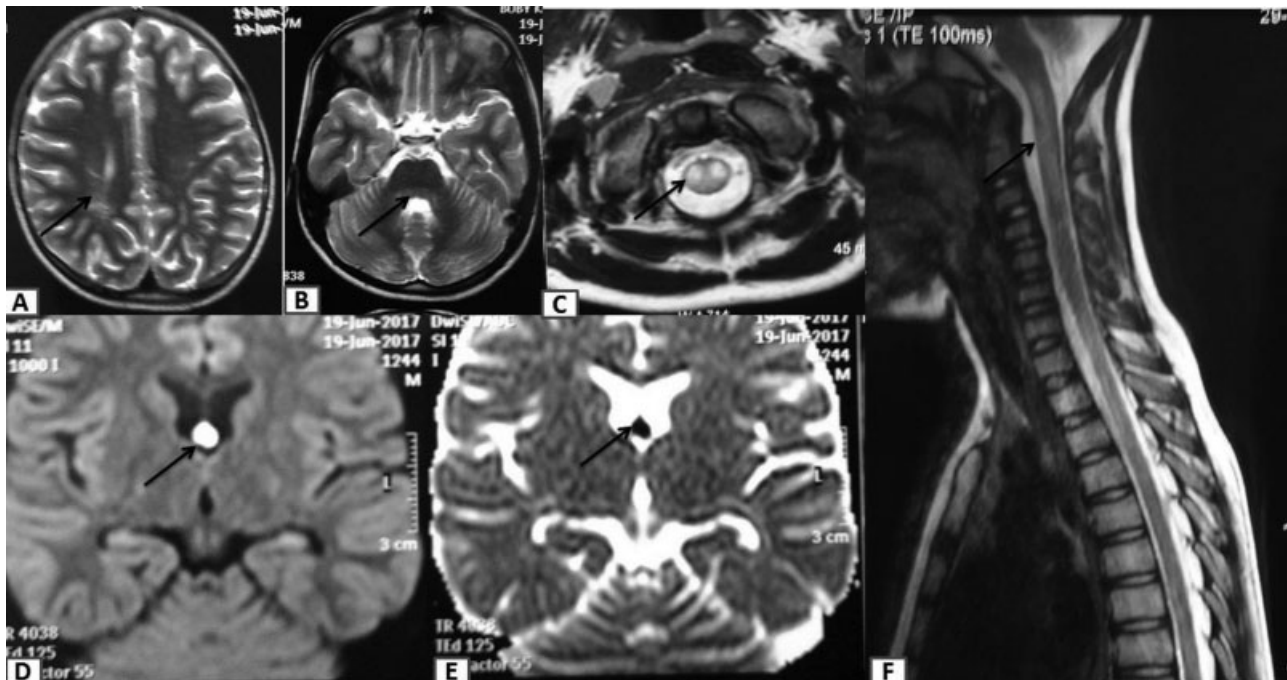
(A) Magnetic Resonance Imaging showing T2 hyperintensities in periventricular white matter, (B) dorsal pons, (C) In Axial-T2 weighted MRI image of cervical cord, this hyperintensity was confined to anterior part mimicking “Owl’s eye”. (D, E) Diffusion restriction was seen in fornix. (F) MRI T2-weighted film, sagittal view of spine, showing longitudinal central T2 hyperintensity from medulla to T1.
